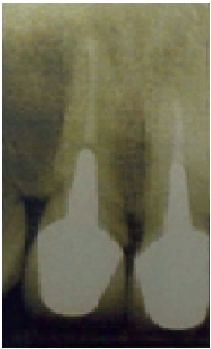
Periapical radiograph shows an over extended root canal filling associated with a periapical radiolucency.
